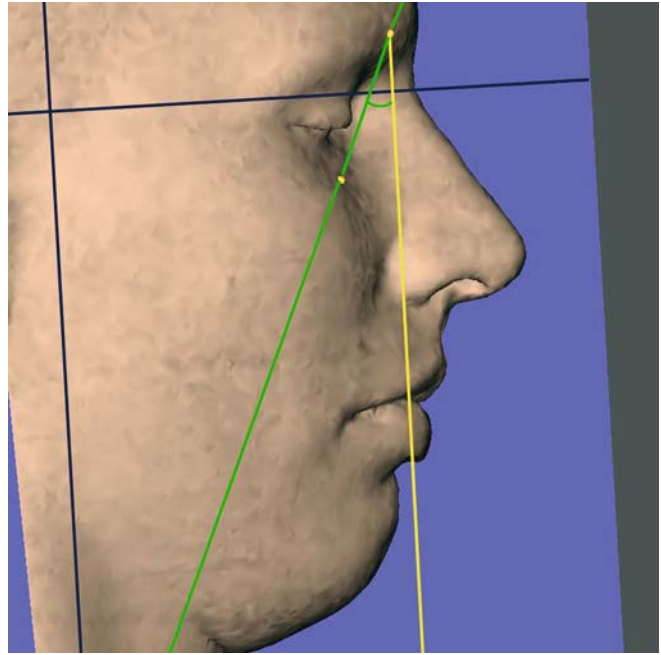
The inclination of the right orbital rim line from the vertical plane, os_{-or} / y -plane, is a projected angular soft tissue measurement on the median (z) 3-D cephalometric reference plane (3-D CT, soft tissues, patient K.C.)
